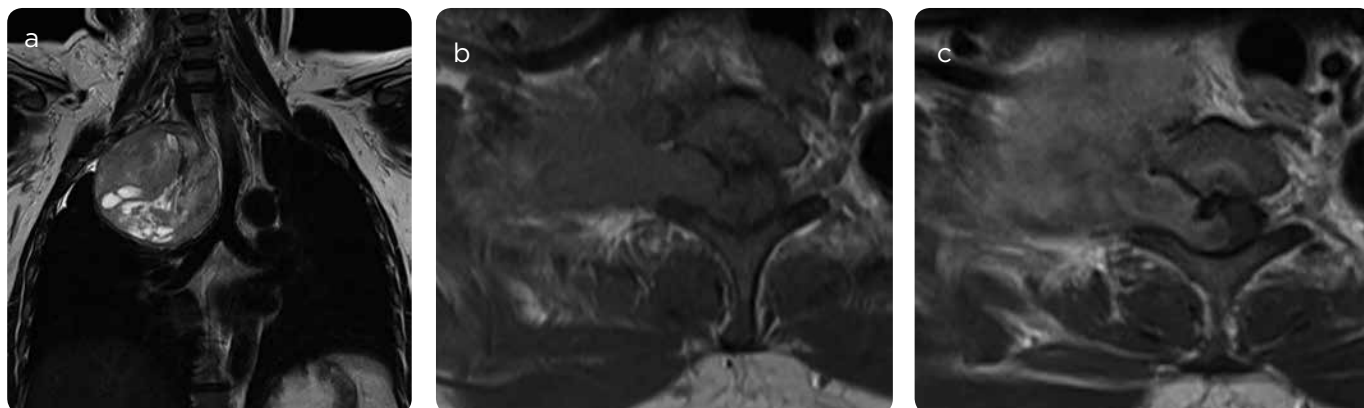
MRI with spinal contrast medium. a) Coronal, with T2 information, b) simple axial with T1 information, c) with contrast medium: right paravertebral mass, heterogeneous, with enhancement, invading the lateral channel of T1-T2. Intradural invasion with compression and displacement of the medullary cord and increase in its signal suggesting myelopathy.
